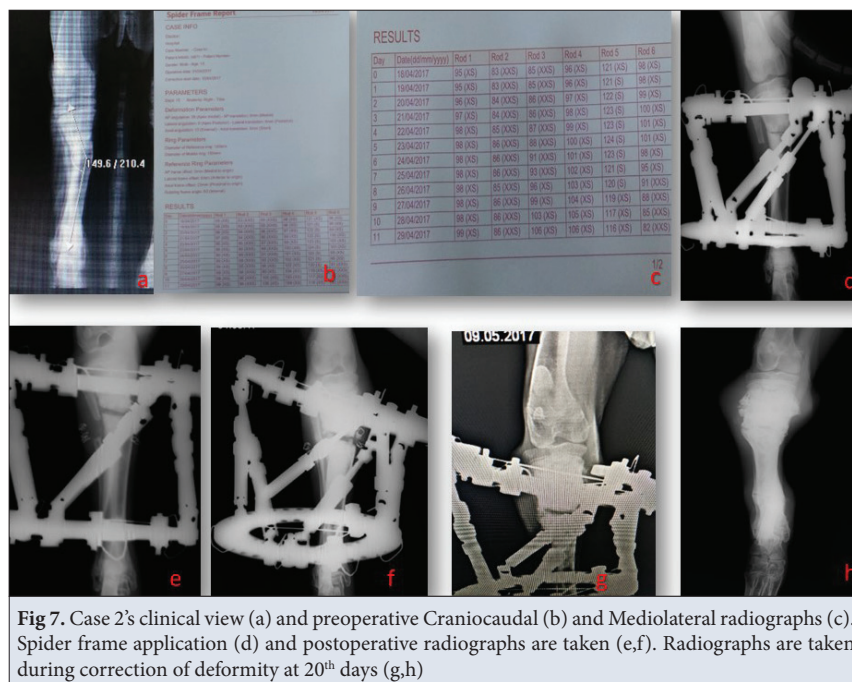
Case 2's clinical view (a) and preoperative Craniocaudal (b) and Mediolateral radiographs (c). Spider frame application (d) and postoperative radiographs are taken (e,f). Radiographs are taken during correction of deformity at 20<sup>th</sup> days (g,h)
